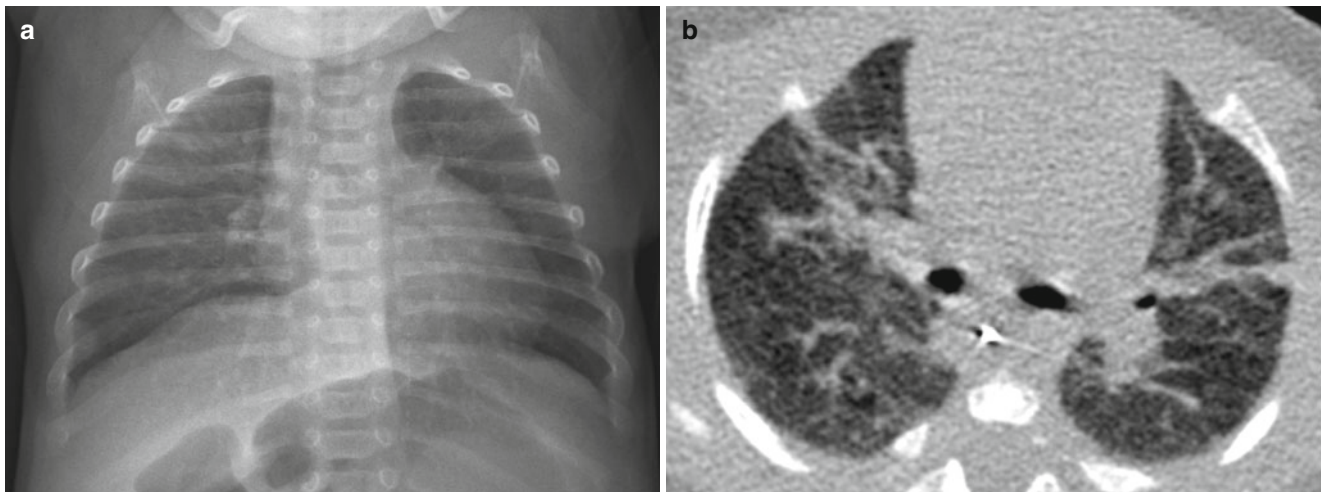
Mild BPD in an 11-week-old infant at a gestational age of 26 weeks. (a) Chest radiograph obtained at the time of discharge shows hyperinflation and fine interstitial opacities. (b) CT performed at the same time shows multifocal linear areas of atelectasis or fibrosis
